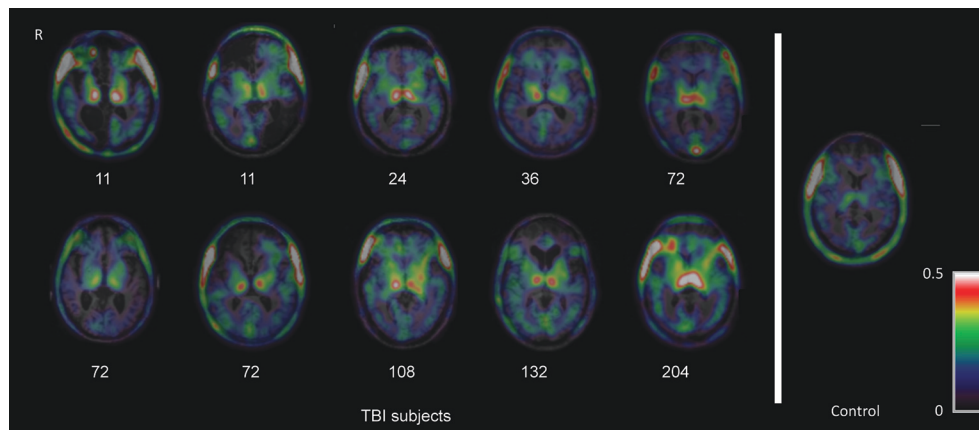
Imaging of chronic microglial activation after TBI. Images of [^{11}C]PK11195 PET images are shown superimposed on the T1 MRI scan at the level of the thalamus for 10 TBI patients, 11 months to 17 years after injury, and a representative control participant. Numbers indicate time since injury (months). *R* = right. The figure has been reproduced with permission of the copyright holder (Ramlackhansingh et al., 2011).
